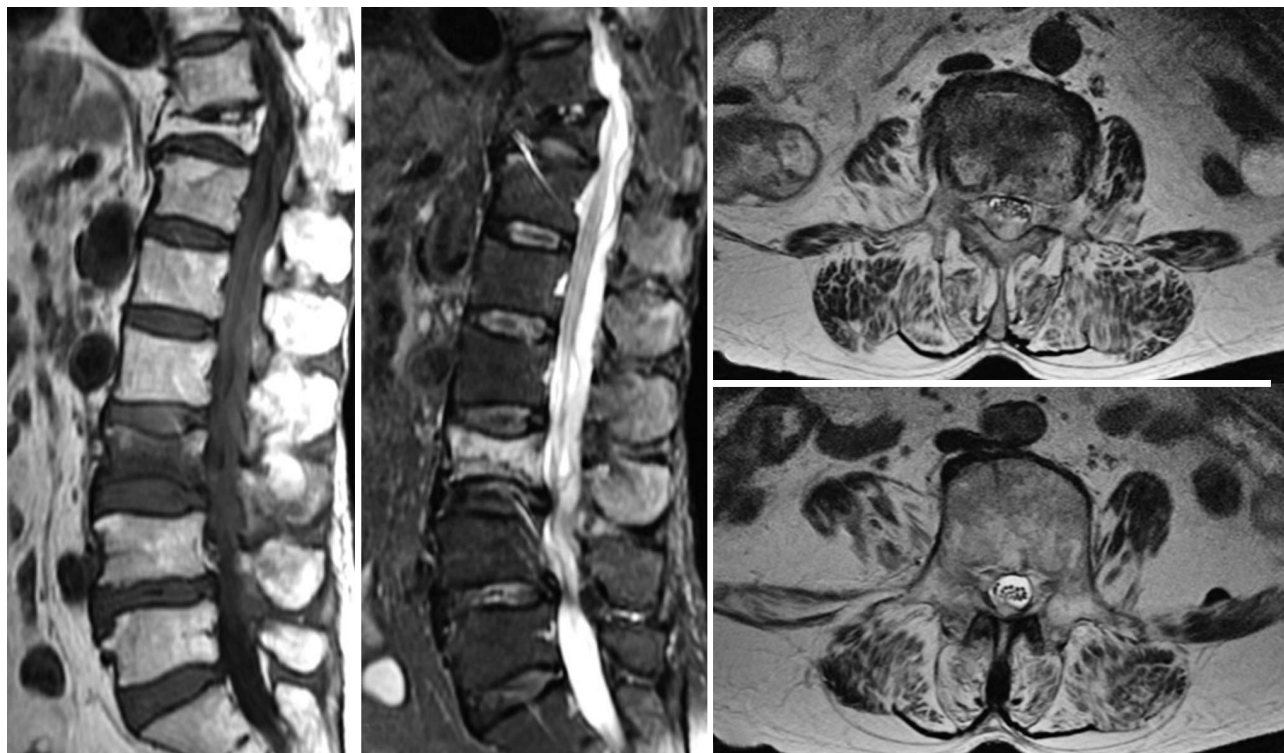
MRI before vertebroplasty demonstrated compression fracture of L3 body with epidural hematoma and old compression fracture of T11 body. There was no evidence of infection.
